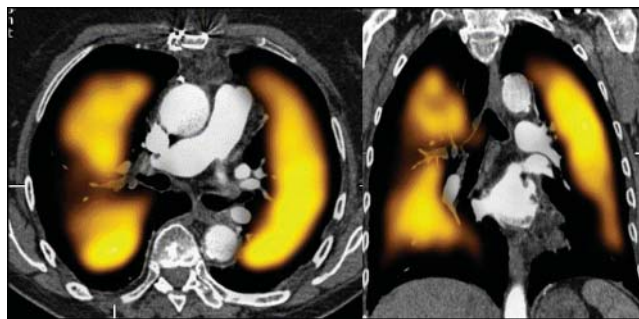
Postacquisition fusion of CT pulmonary angiography and SPECT ventilation/perfusion scintigraphy showing a wedge-shaped defect in the blood flow to the right lung in a patient suspected of having a pulmonary embolism.
